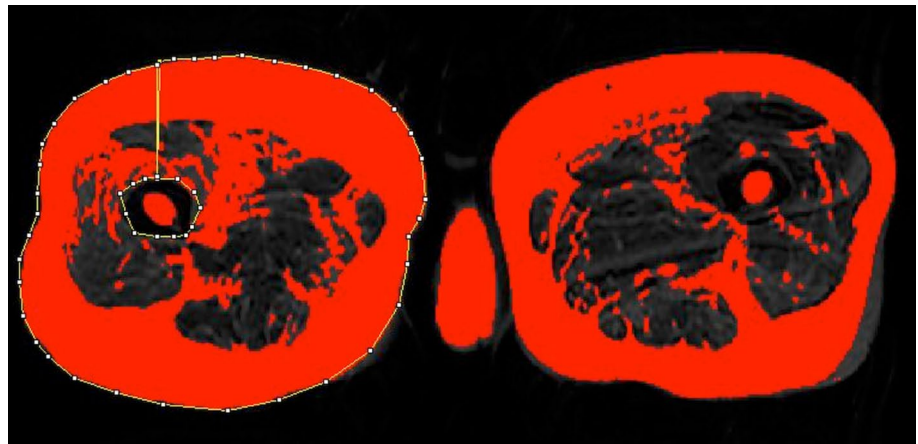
Calculation of the muscle volume of the right vastus lateralis (VL), vastus medialis (VM), rectus femoris (RF), and vastus intermedius on single axial T2-weighted MRI
